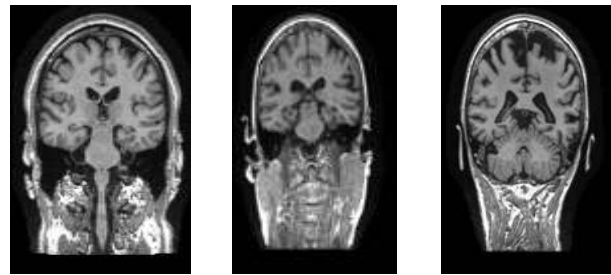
Sample MRI images representing stages (shown from left to right): CN, MCI, and AD.
